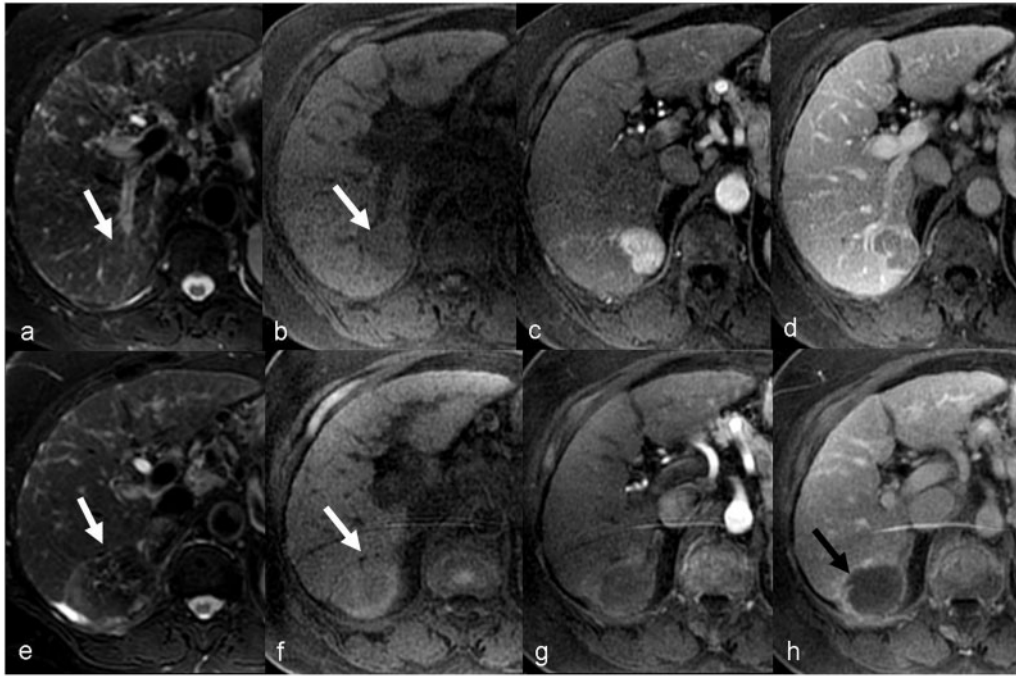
MR appearances of HCC before and after RF ablation. Before ablation (a–d), HCC is iso- to mildly hyperintense on the T2-weighted image (a), hypointense on the T1-weighted image (b), enhances in the arterial phase (c) and washes out in the portal venous phase (d). Post-ablation MRI (e–h) after 4 weeks showing a larger heterogeneous hypointensity on the T2-weighted image (e) and mixed hyperintensity on the T1-weighted image (f) representing the ablation zone (white arrows). There is no enhancement in the arterial phase (g) but a thin rim of post-ablation inflammatory enhancement (black arrow) seen in the portal venous phase (h).
